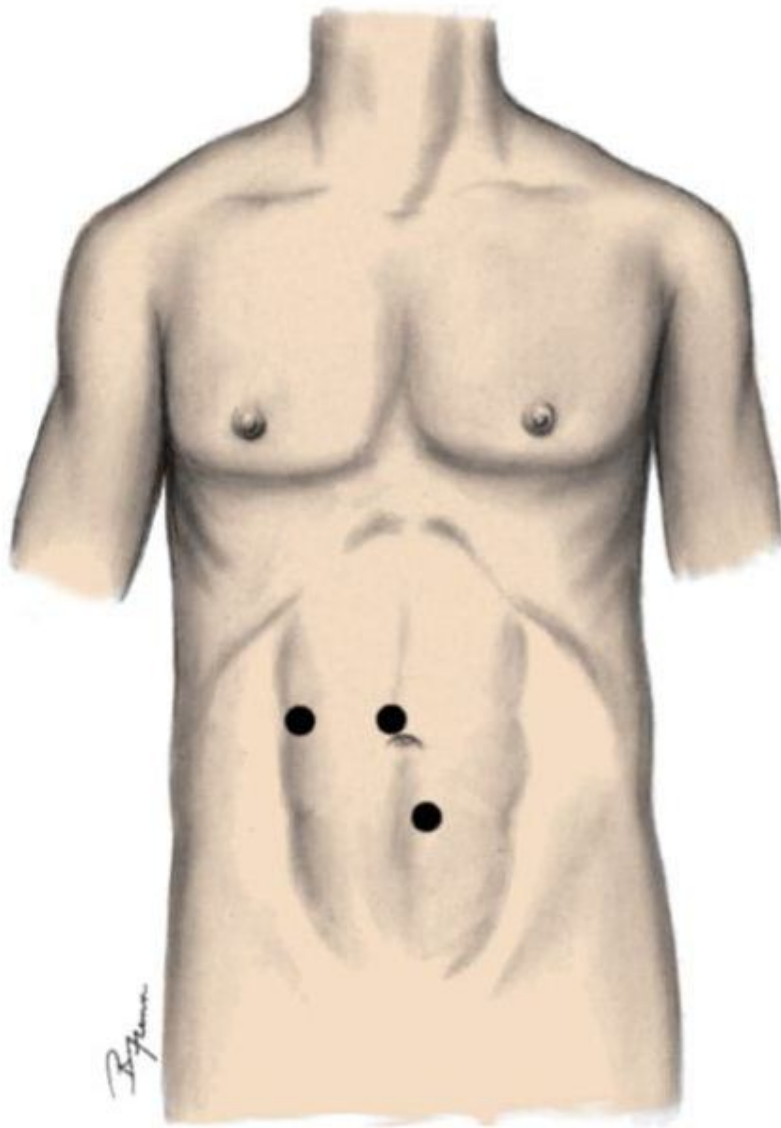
Trocar placement for laparoscopic appendectomy. Additional trocars can be placed in the right upper or left lower quadrants. (*From Frantzides CT: Laparoscopic and Thoracoscopic Surgery. St. Louis, Mosby-Year Book, 1994, p 66.*)
